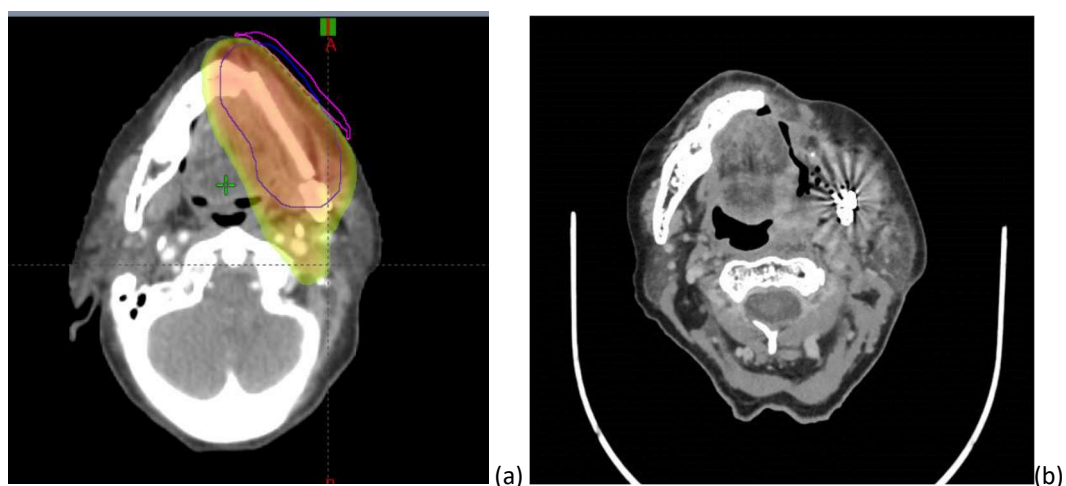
Axial CT images from patient diagnosed with local recurrence after receiving treatment on NICO study. a) radiotherapy planning scan with area in orange demonstrating high dose PTV and b) diagnostic scan at local recurrence..
